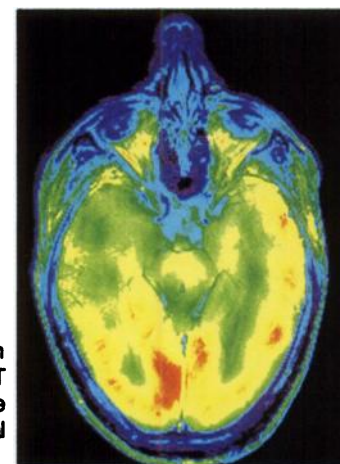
Superimposition of MRI and ^{99m}Tc -ECD-SPECT (slices angulated parallel to the long-axis of the temporal lobes).
